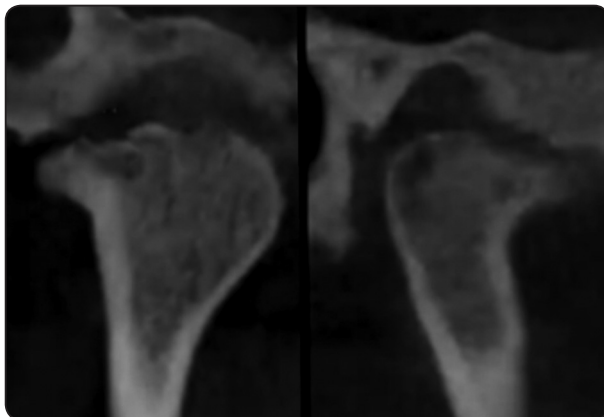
Preoperative CT scan showing bony erosions in the condyle and eminence.
